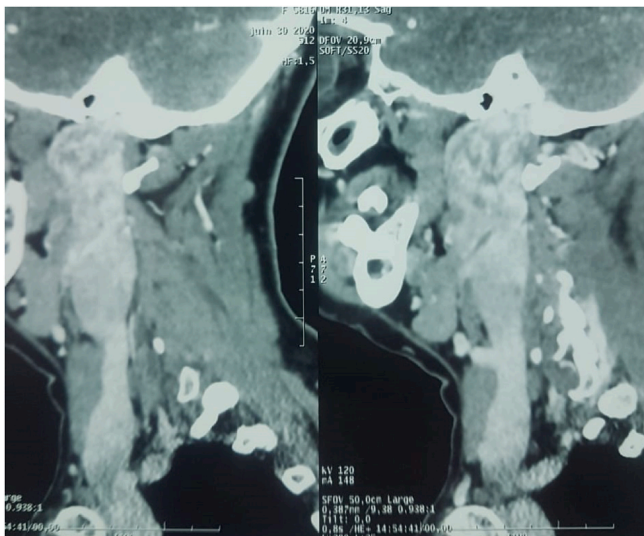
Cervical CT scan showing a strongly enhancing mass of the right internal jugular vein extending into jugular foramen without any bone destruction.
